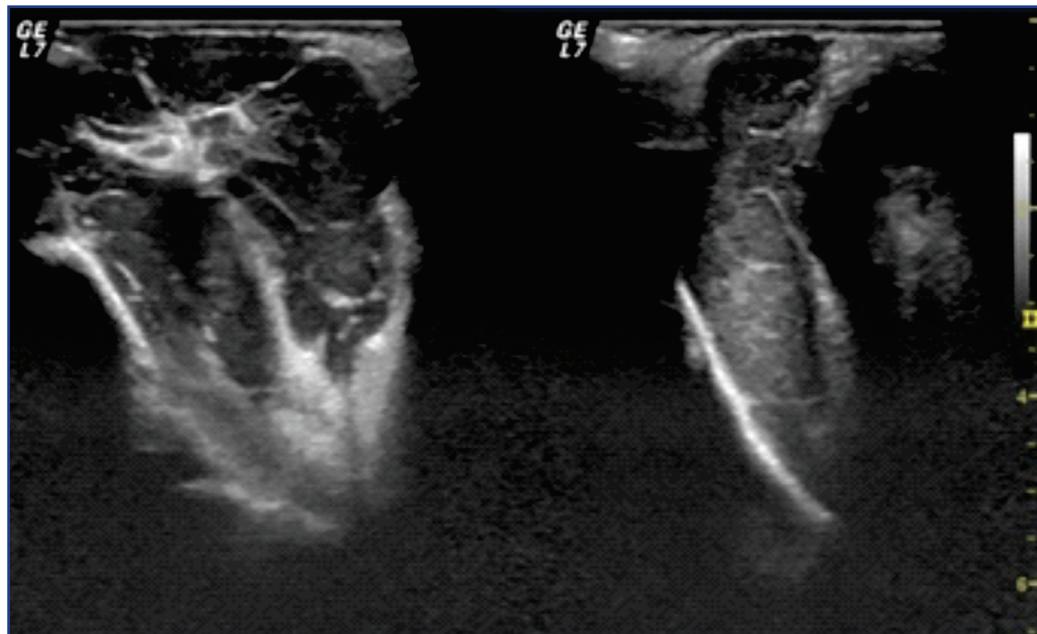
Ultrasonography, Patient A., 67 years. Lymphoma of the orbit
